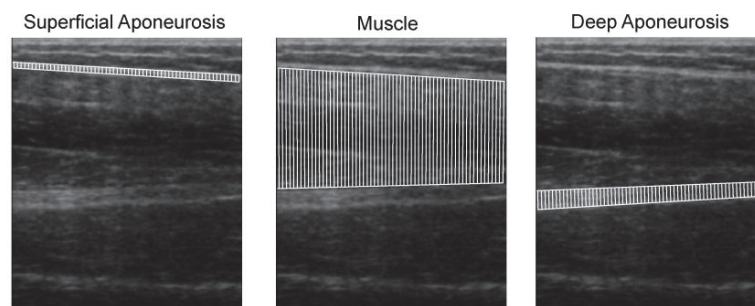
(A) Representative examples of a series of ultrasound images obtained at the different measurement sites along the thigh length for the biceps femoris. (B) Example of ultrasound images of biceps femoris muscle indicating region of interest as well as the placement of the landmarks to measure muscle and aponeurosis thickness. The fit provided set of landmarks, comprising x- and y-coordinates of 60 evenly spaced pixel points spanning the entire width of the region of interest. The white vertical lines represent thickness measures.
